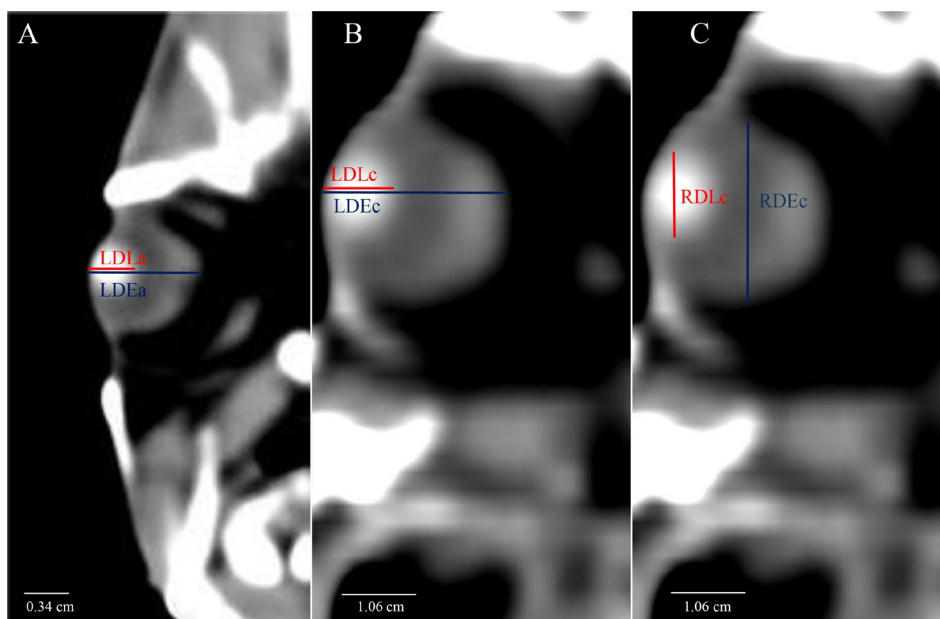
Computed tomography images in axial (A) and coronal (B and C) sections of Nile tilapia. (A) Axial measurements of the lateromedial distance of the eyeball (LDEa) and lateromedial distance of the lens (LDLa); (B) Transverse coronal measurements of the lateromedial distance of the eyeball (LDEc) and lateromedial distance of the lens (LDLc); (C) Longitudinal coronal measurements of the rostrocaudal distance of the eyeball (RDEc) and rostrocaudal distance of the lens (RDLc).
